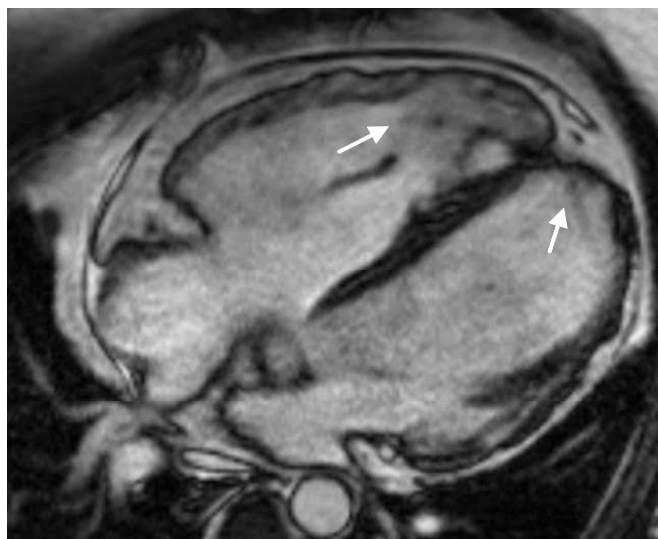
Fibrofatty infiltration of RV apex and LV apicolateral wall in cardiac MRI
